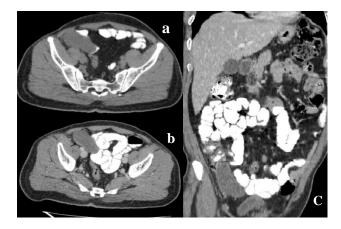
Case 1- axial unenhanced (a) contrastenhanced; (b) CT scan images show tubular cystic right lower quadrant mass (black arrows). Coronal contrast-enhanced; (c) CT scan image shows right lower quadrant tubular cystic mass.
